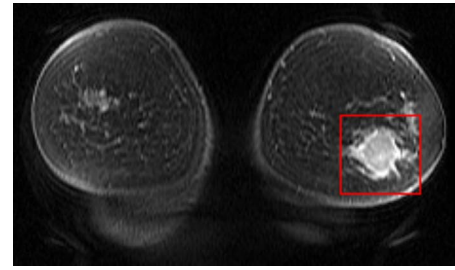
A 2D postcontrast breast MRI slice. The prechemotherapy mass was enclosed by the rectangular ROI drawn by the radiologist.
